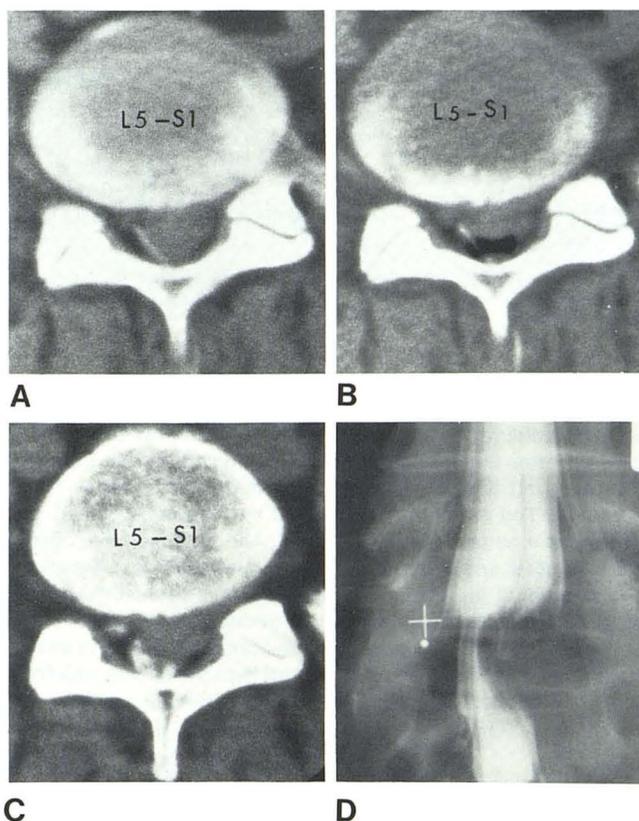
Case 10. A, plain CT at L5-S1 disk level shows asymmetry of thecal sac but fails to demonstrate herniated disk. B, Air CT. Air column in thecal sac is deformed and displaced posteriorly, outlining soft-tissue mass. C, Metrizamide-enhanced CT. Thecal sac is narrowed and displaced posteriorly by large herniated disk. Right root sleeve is visualized. D, Metrizamide myelography demonstrates severe herniation at L5-S1 disk level.
